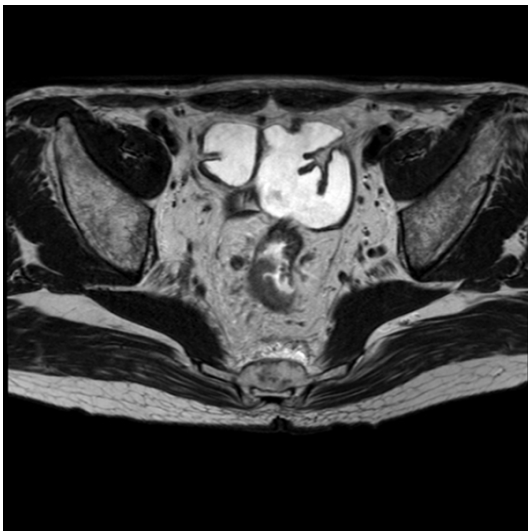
Representative pelvic magnetic resonance imaging (MRI) scan from an axial T2WI sequence. Right rear wall of the upper rectal segment is normally closed and thickening. Equisignal T2WI scan shows slightly higher signal intensity, muscularis propria signal is not continuous, and lymph nodes (diameter = 6 mm) are in mesentery fascia next to the right side of the intestine.
